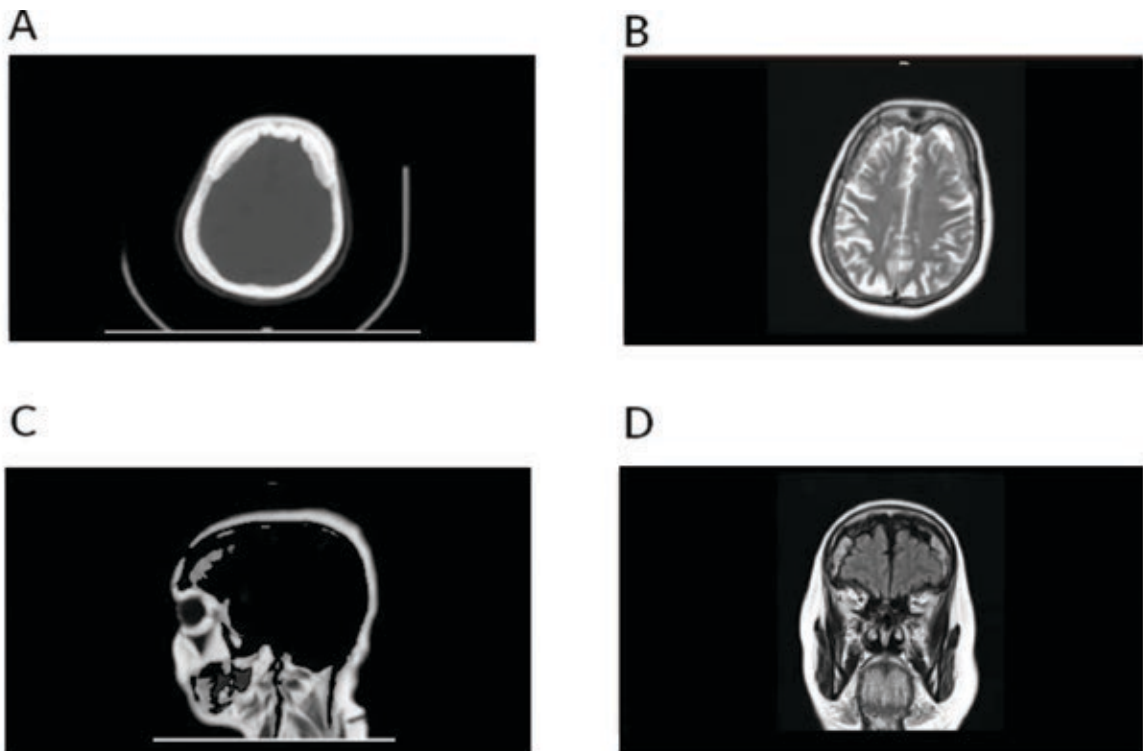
CT and MRI Brain Plain Images
